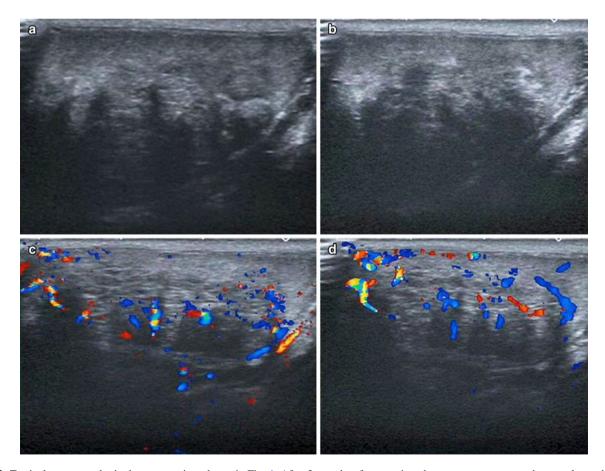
Testicular sonography in the same patient shown in Fig. 1. After 2 months of appropriate therapy, repeat sonography reveals no changes in the B-mode examination (a, b). The hypervascularity is still evident, but much less intense than it was on the previous examination (c, d)
